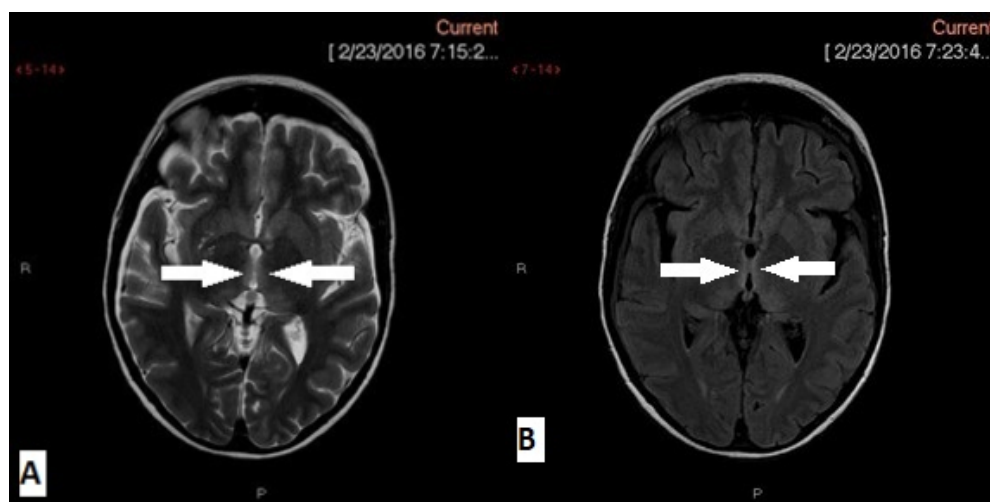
(A, B): Axial T2-weighted/FLAIR images show symmetrically increased signal intensity in the periventricular region of the third ventricle
